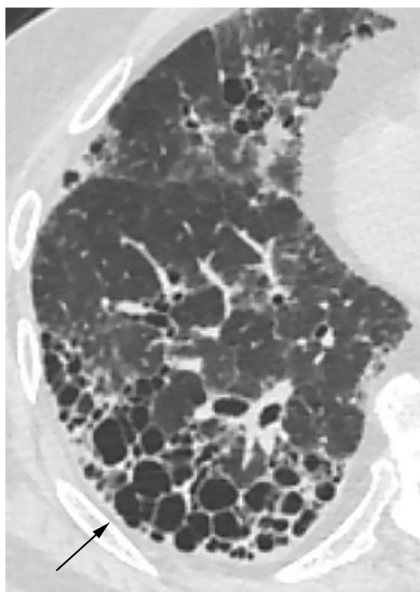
HRCT of a patient with rheumatoid arthritis shows subpleural and basal predominant honeycombing (*arrow*), reticular abnormality, and mild traction bronchiolectasis consistent with a UIP pattern. HRCT high-resolution computed tomography, UIP usual interstitial pneumonia
